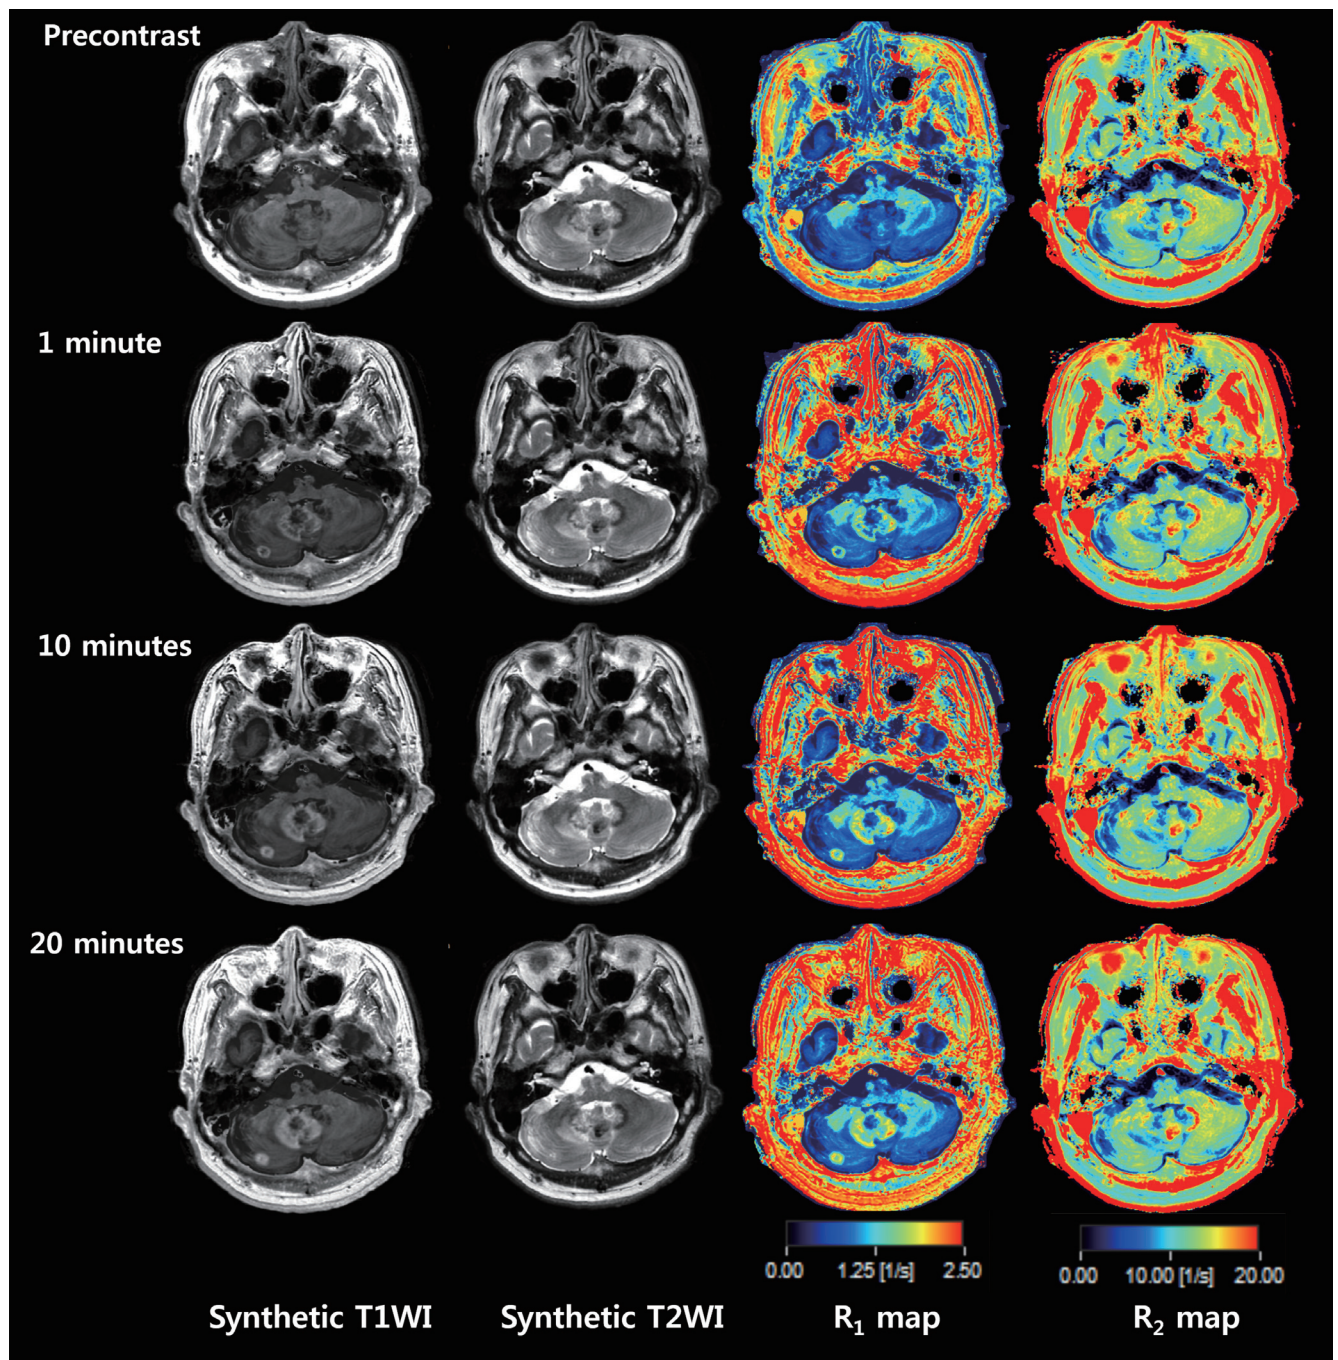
Representative pre- and post-contrast synthetic T1WI and quantitative R_1 and R_2 maps with different delay times in 63-year-old male patient with brain metastasis. R_1 = longitudinal relaxation rate, R_2 = transverse relaxation rate, T1WI = T1-weighted image, T2WI = T2-weighted image
